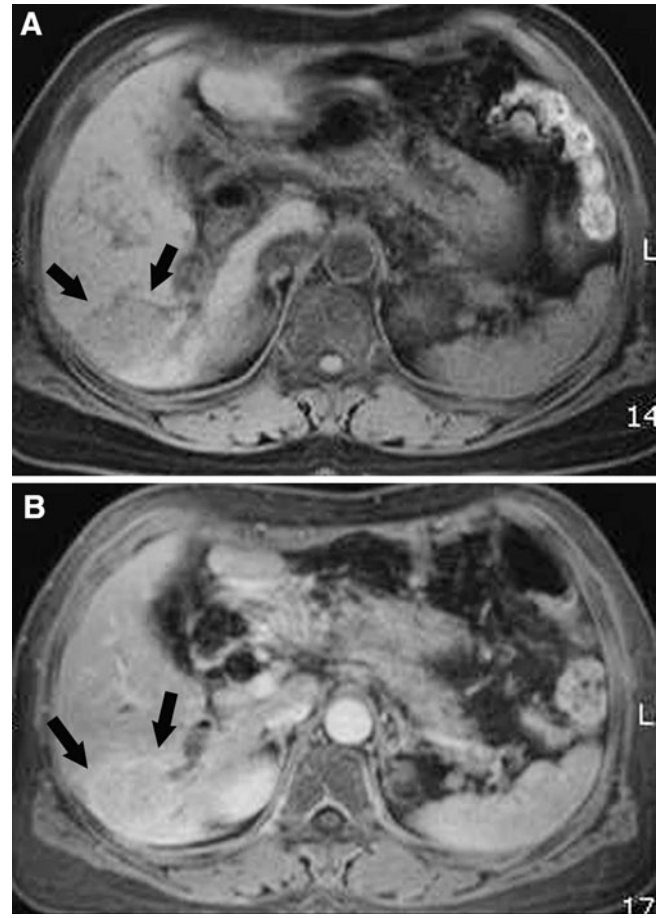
Hepatic inflammatory pseudotumor associated with RPC in a 51-year-old woman who complained of abdominal pain and fever. She had a history of recurrent attacks of cholangitis. A T1-weighted fat suppression FLASH MR image demonstrates low signal intensity mass (*arrows*) in the posterior segment of the right lobe (*arrows*). B Contrast-enhanced MR image during the portal phase shows a thin and lobulated enhancement at the periphery of the mass (*arrows*). The diagnosis of cholangiocarcinoma was made by surgical resection.
